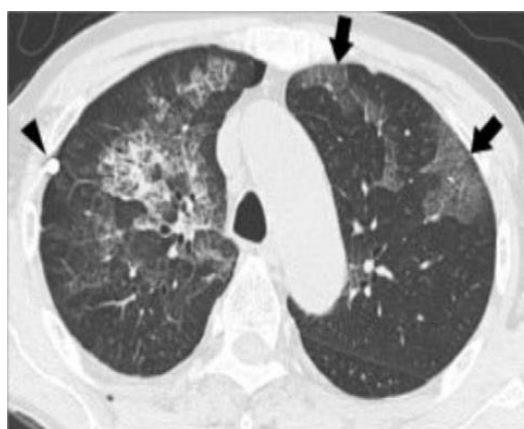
The axial HRCT image demonstrates bilateral ground-glass opacities with superimposed interlobular septal thickening, producing a "crazy-paving" pattern (indicated by arrows). The involvement is relatively diffuse and peripheral, without obvious cardiomegaly or pleural effusion.
